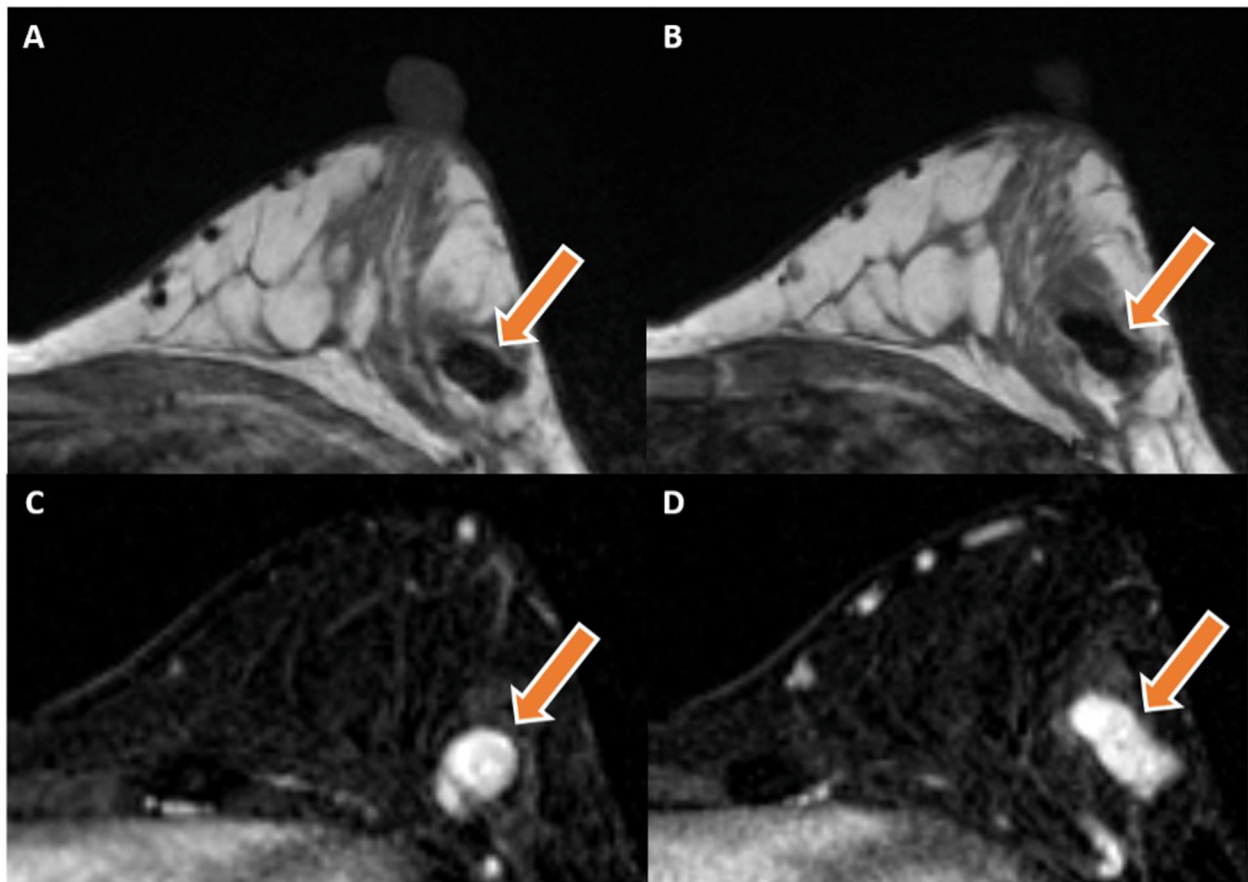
Images (A) and (B) axial T1 weighted MRI views of the left breast demonstrate large flow voids (orange arrows) in the outer central breast in the region of recent biopsy. Images (C) and (D) axial postcontrast T1 weighted subtraction views show brisk enhancement (orange arrows) in the previously identified flow voids in the location of the recently biopsied left breast mass.
